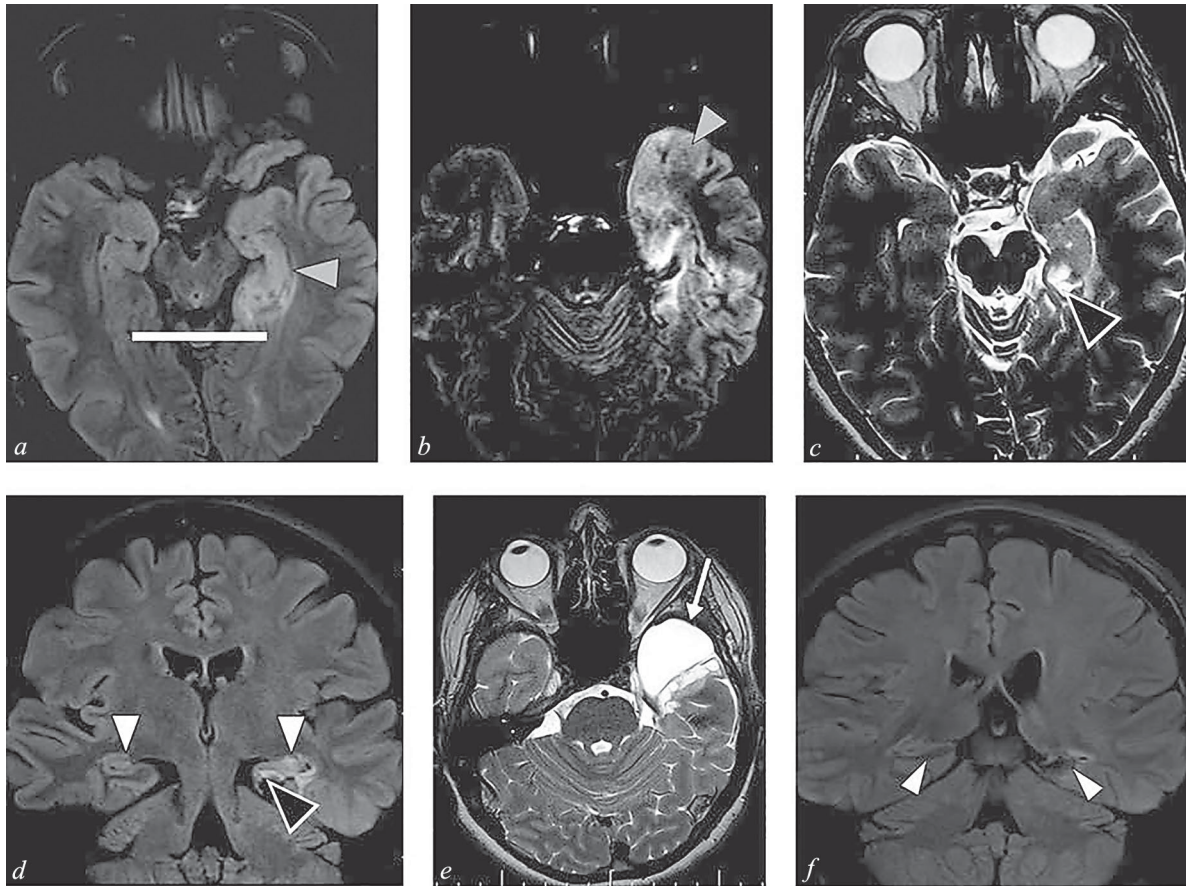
MRI, clinical case 2. See text for details.
